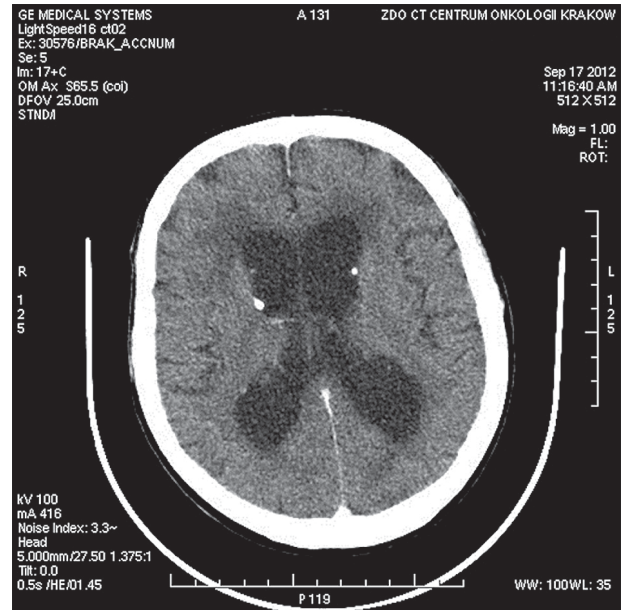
CT scan – subependymal calcifications in lateral ventricles
